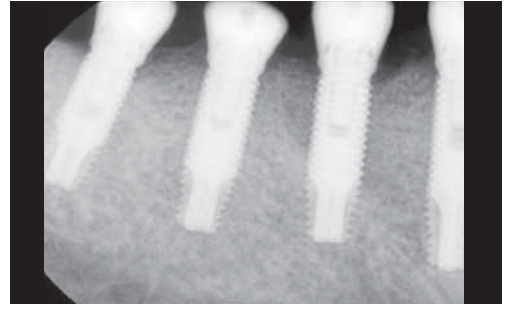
Postoperative radiographic view verifies crestal level of peri-implant bone.
